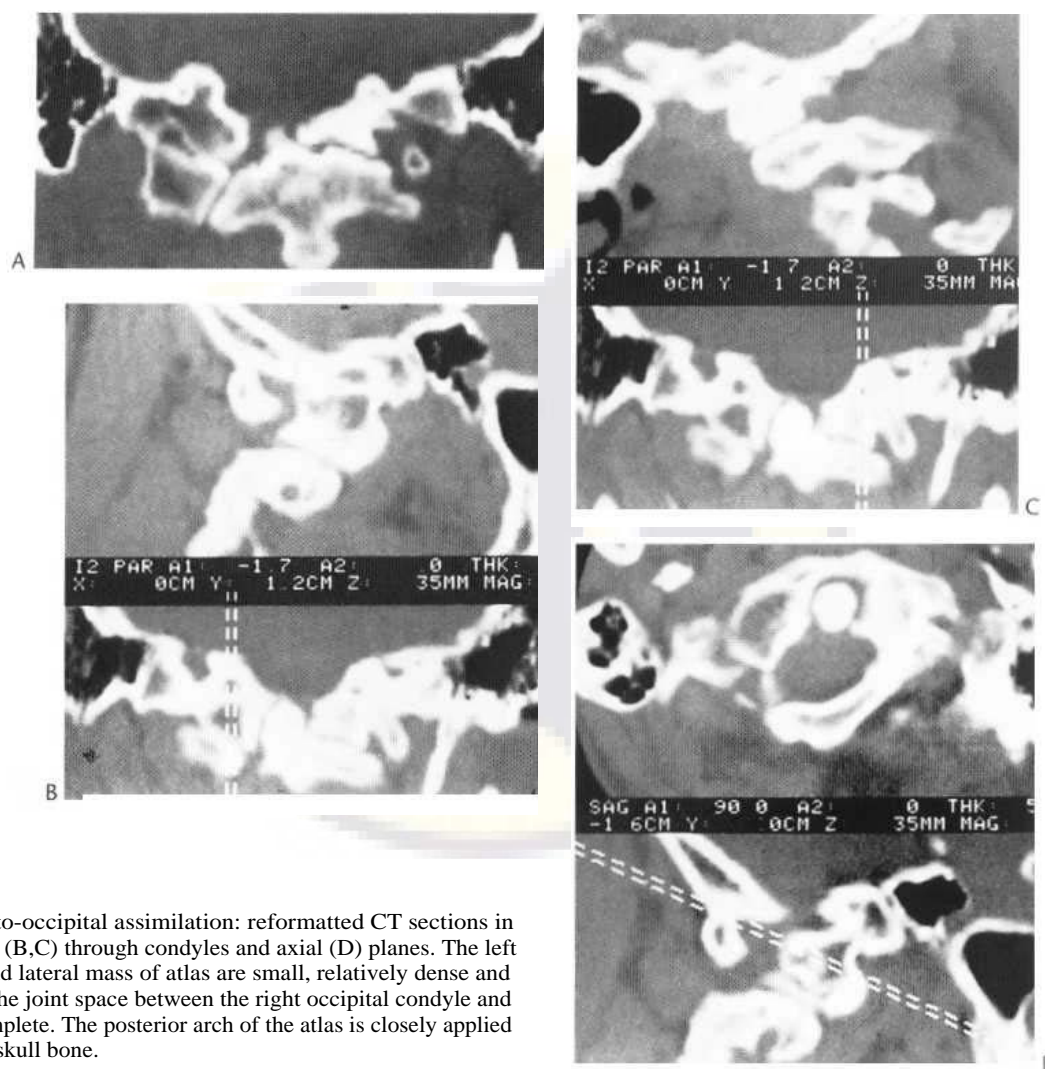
Atlanto-occipital assimilation: reformatted CT sections in coronal (A), sagittal (B,C) through condyles and axial (D) planes. The left occipital condyle and lateral mass of atlas are small, relatively dense and completely fused. The joint space between the right occipital condyle and lateral mass is incomplete. The posterior arch of the atlas is closely applied but not fused to the skull bone.
